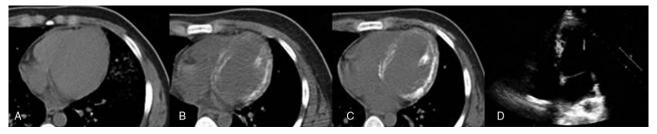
(A) Computed tomography (CT) scan showing no morphological abnormalities in the left ventricular wall on the day of admission. (B) Follow-up CT scan (10 days after admission) showing the left ventricular wall with increased density. (C) CT scan 30 days after admission showing extensive myocardial calcifications in the left ventricular wall with clearly increased density. (D) Echocardiography did not detect the myocardial calcifications. CT = computed tomography.
